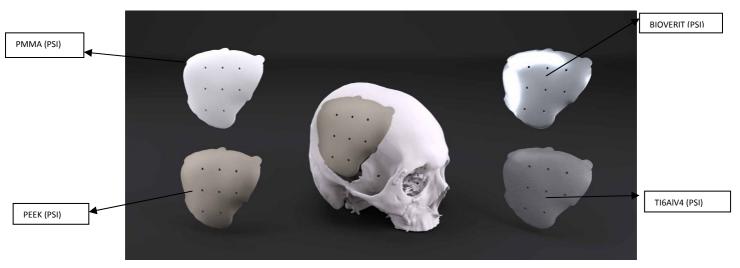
Intracranial implants PSI (Patient Specific Implants – custom made) from different materials, using the same CT acquisition data^{7,9}.
